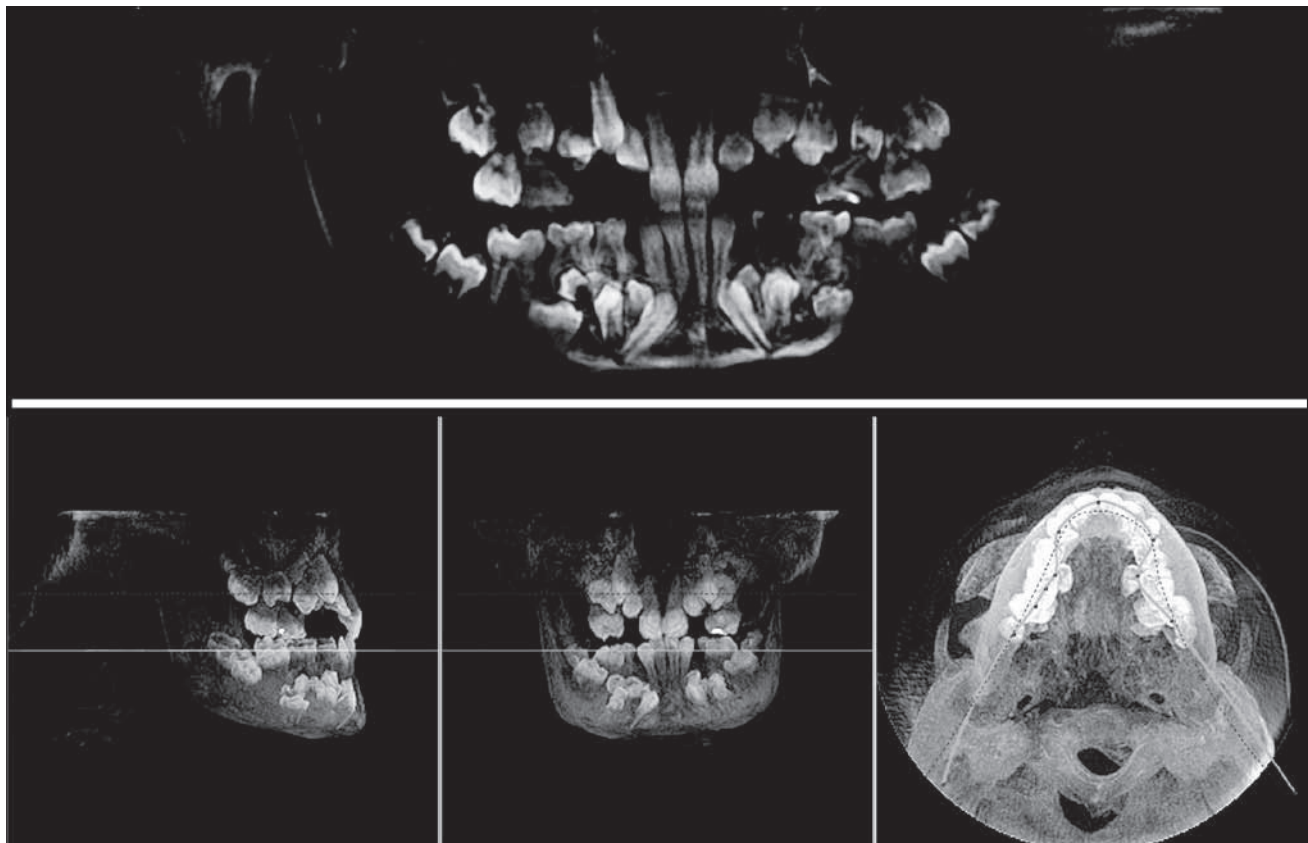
The Conic CT scan showing the location of supernumerary teeth.
